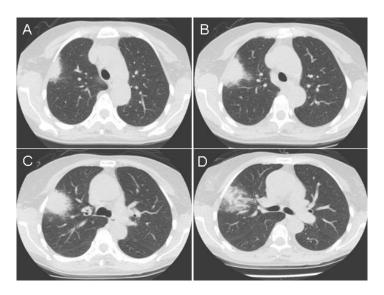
Representative axial images from thoracic CT scan in lung windows.
